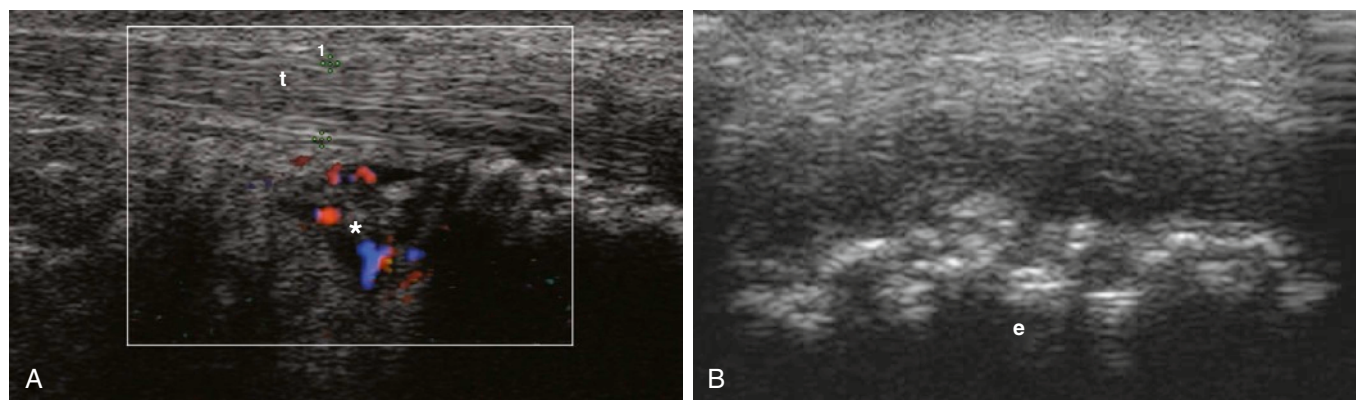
Scans show enthesopathy of the Achilles tendon (t) with power Doppler–positive bursitis subachillae (star) (grade 2) and erosions (e) on the calcaneal bone in longitudinal (A) and transverse (B) views.
